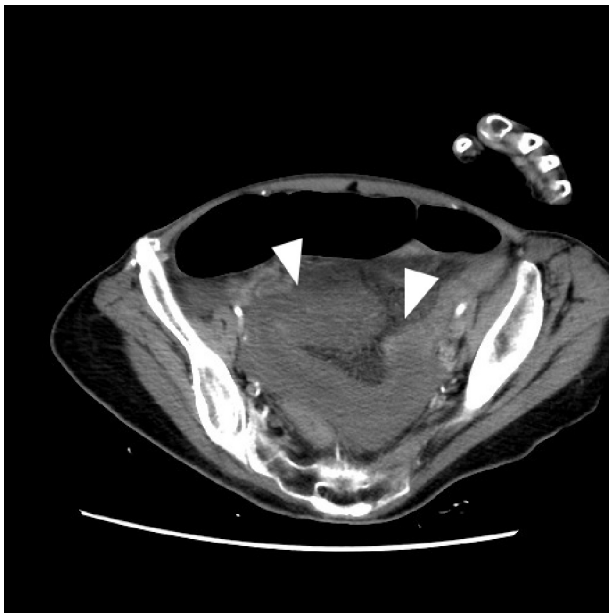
Computed tomography showing a closed loop of the small bowel in the pelvis (arrowheads).
